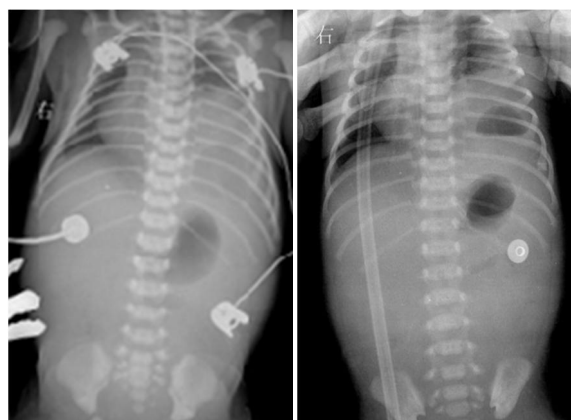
Left: Supine radiography showing an opacified left lower lung field with a cyst and a diffuse ground-glass opacity with paucity of bowel gas; Right: Erect radiography showing gas fluid level in the left hemithorax.
